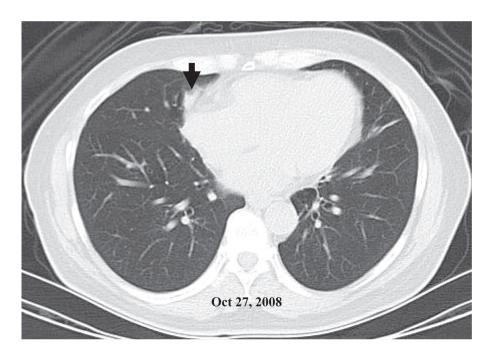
CT Chest shows small pulmonary atelectasis at right middle lobe.
